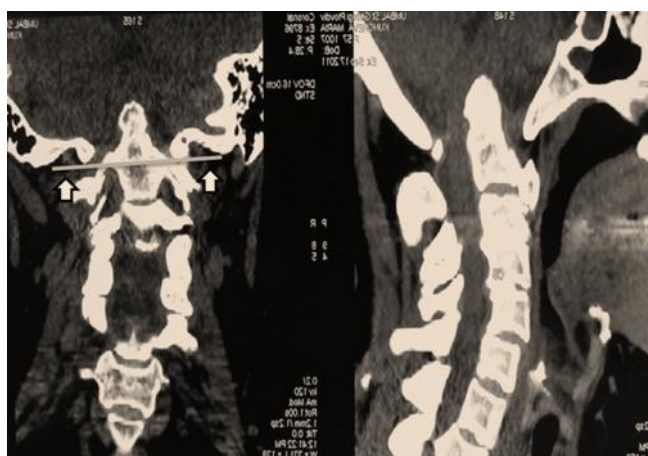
CT image of basilar invagination – dens axis migrates upward and enters the posterior cranial fossa. The top of dens axis exceeds the Chamberlain's line on the sagittal image (not shown). The top of C2 is normally at or below this line
